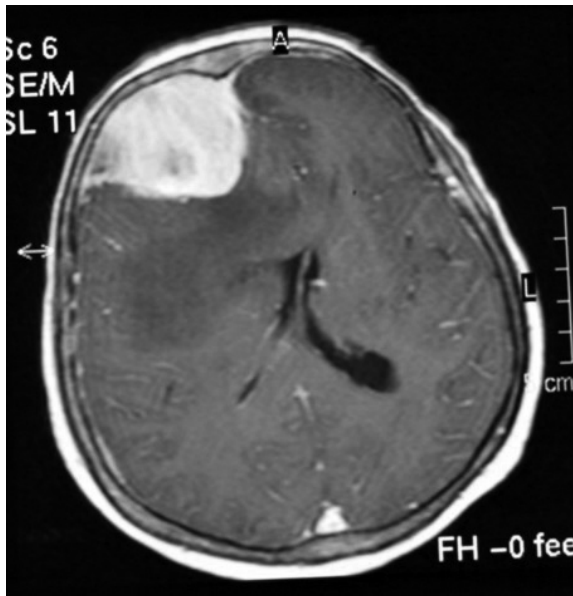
On magnetic resonance imaging of the brain, a right-sided mass lesion that appeared to originate from the meninges was associated with intense oedema that resulted in left-sided shift of the midline structures. Following intravenous administration of the contrast medium, the mass lesion demonstrated notable contrast enhancement. The presumptive diagnosis of a convexity meningioma was made (T2-weighted trans-axial image following intravenous administration of the contrast medium).
